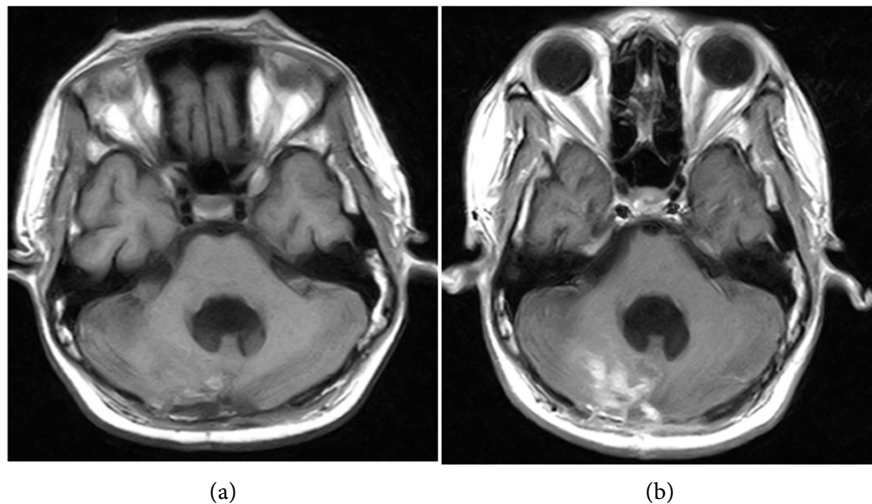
Postoperative MRI showing a gross total resection of the tumor. (a) Without contrast; (b) With contrast.
